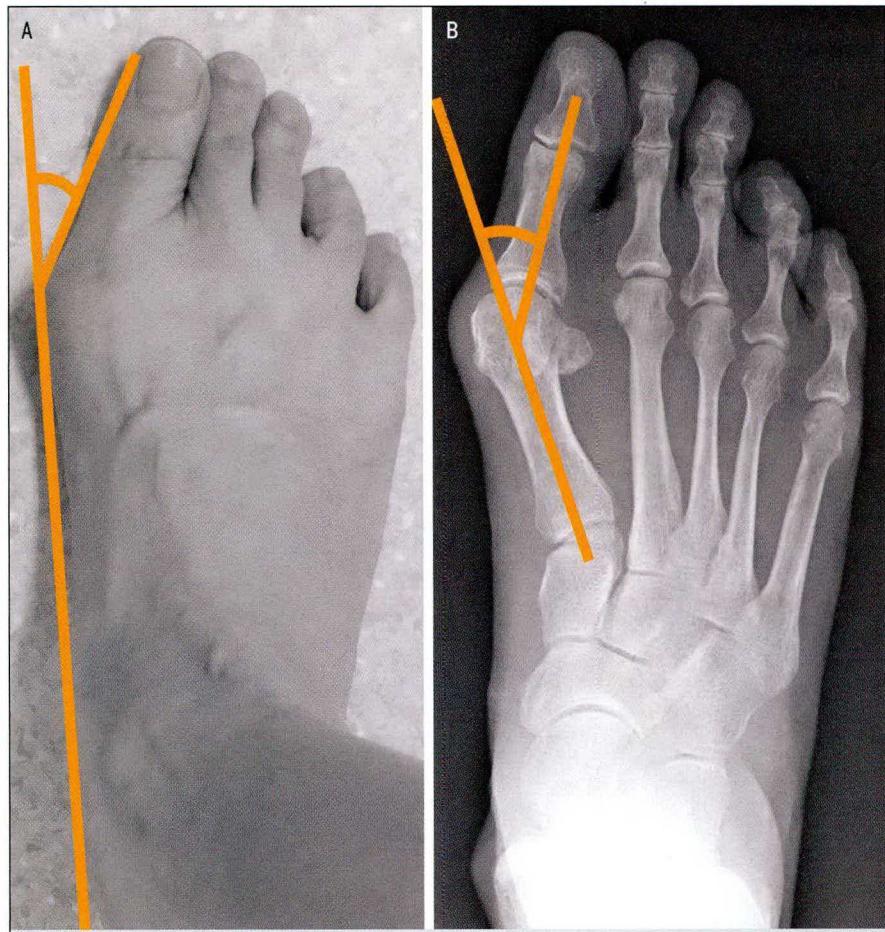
Measurements of (A) photographic hallux valgus angle (28.5°) and (B) radiographic hallux valgus angle (30.5°).
